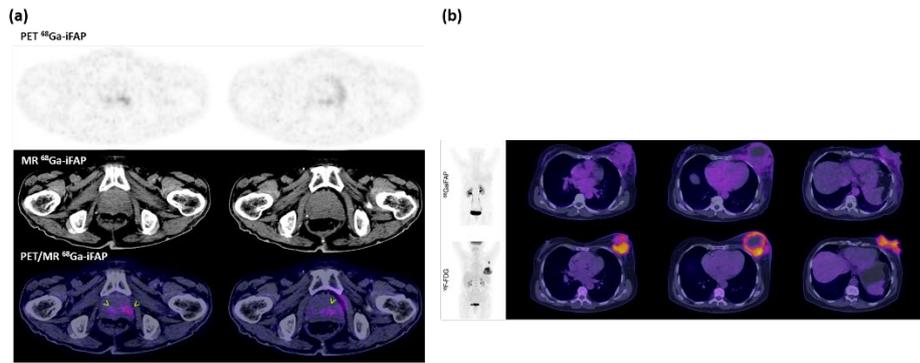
(a) Patient diagnosed with high-grade glioblastoma exhibiting radiopharmaceutical ⁶⁸Ga-iFAP uptake in lesion associated with prostate cancer. (b) Comparative imaging of radiopharmaceuticals ⁶⁸Ga-iFAP and ¹⁸F-FDG uptake in a patient with triple-negative breast cancer.
